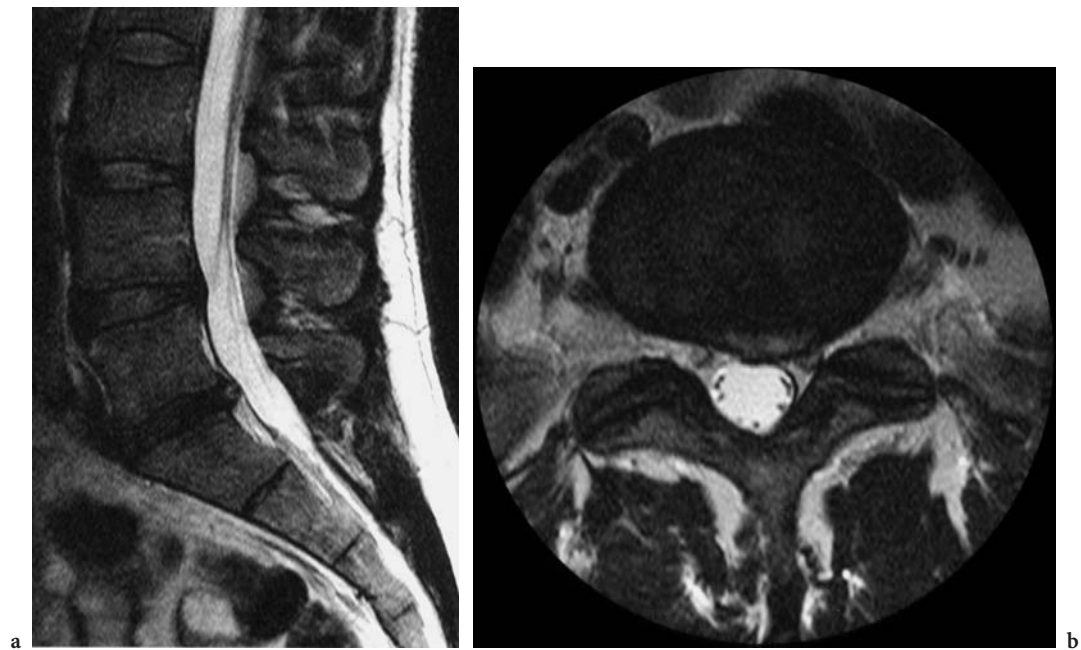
Broad-based lumbar disc protrusion at L5–S1 in a 44-year-old man. Sagittal (a) and axial (b) T2-weighted images. The protruding disc presents an increased signal intensity on these T2-weighted images, indicating an area of myxoid degeneration. The left lateral recess is narrowed, and the left S1 nerve root is displaced
